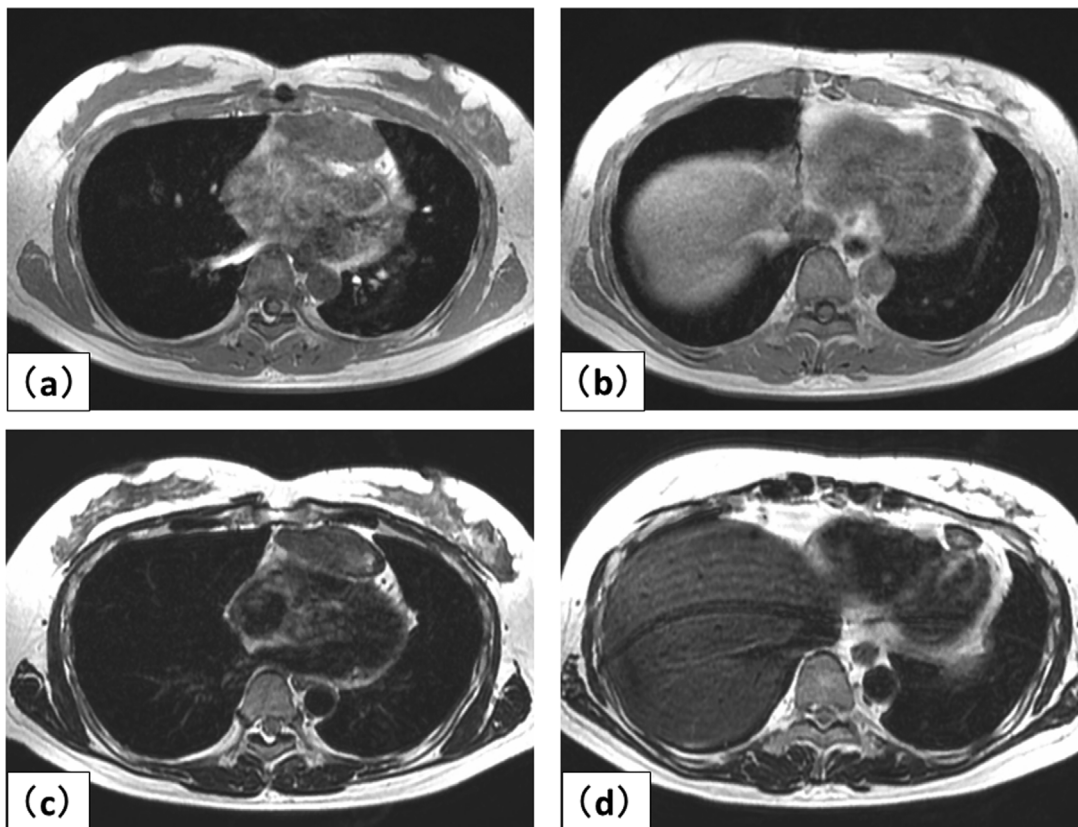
Magnetic resonance imaging (MRI) findings. (a) A T1-weighted image (T1WI) demonstrated a well-defined isointense mass. (b) A T2-weighted image (T2WI) demonstrated a mixture of isointense and hyperintense areas.
